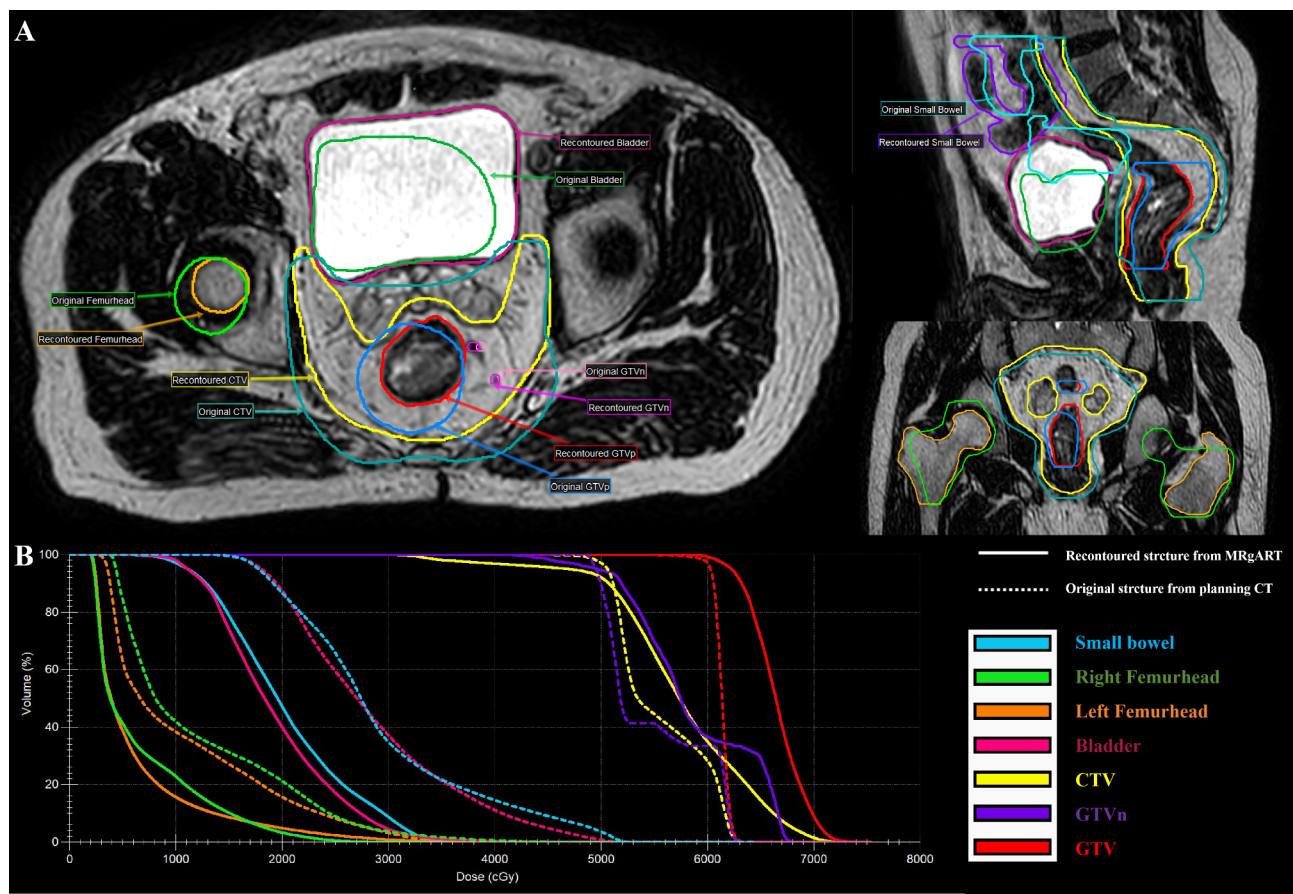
The difference between online adaptive contouring on MR images and using the original contour from planning CT images. (A) The upper image demonstrates the transfer of the planning CT by rigid alignment to the MR scanned prior to daily radiotherapy, highlighting the ability of adaptive radiotherapy to adjust to anatomical changes on the same day. (B) The dose–volume histogram (DVH) displays the relevant organs at risk (OAR) and tumor targets in corresponding colors using dashed lines for the original plan based on CT and solid lines for the optimized plan based on MR. The optimized plan improves target coverage while reducing the dose to the OAR
